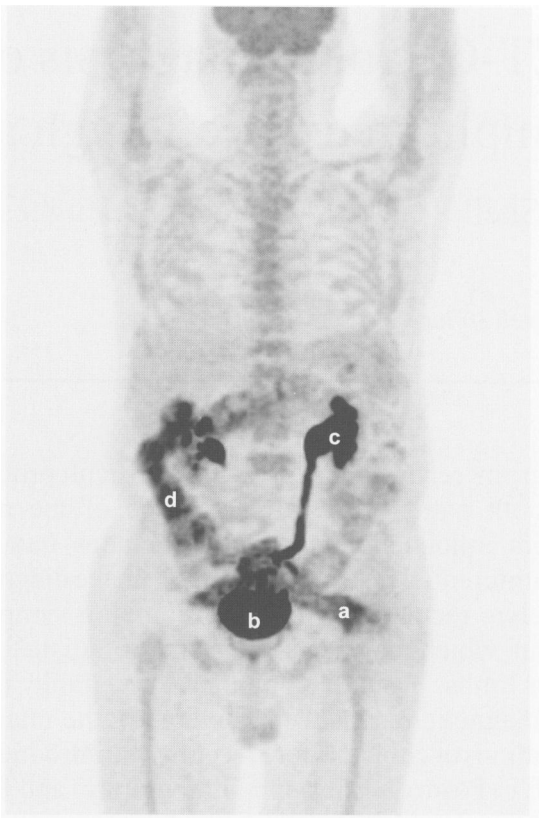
Maximum Intensity Projection (MIP) of the FDG-PET data (coronal section) demonstrating enhanced activity extending laterally to the left from the pelvis (a). Normal FDG activity is seen in the bladder (b), left kidney and ureter (c) and colon (d).
